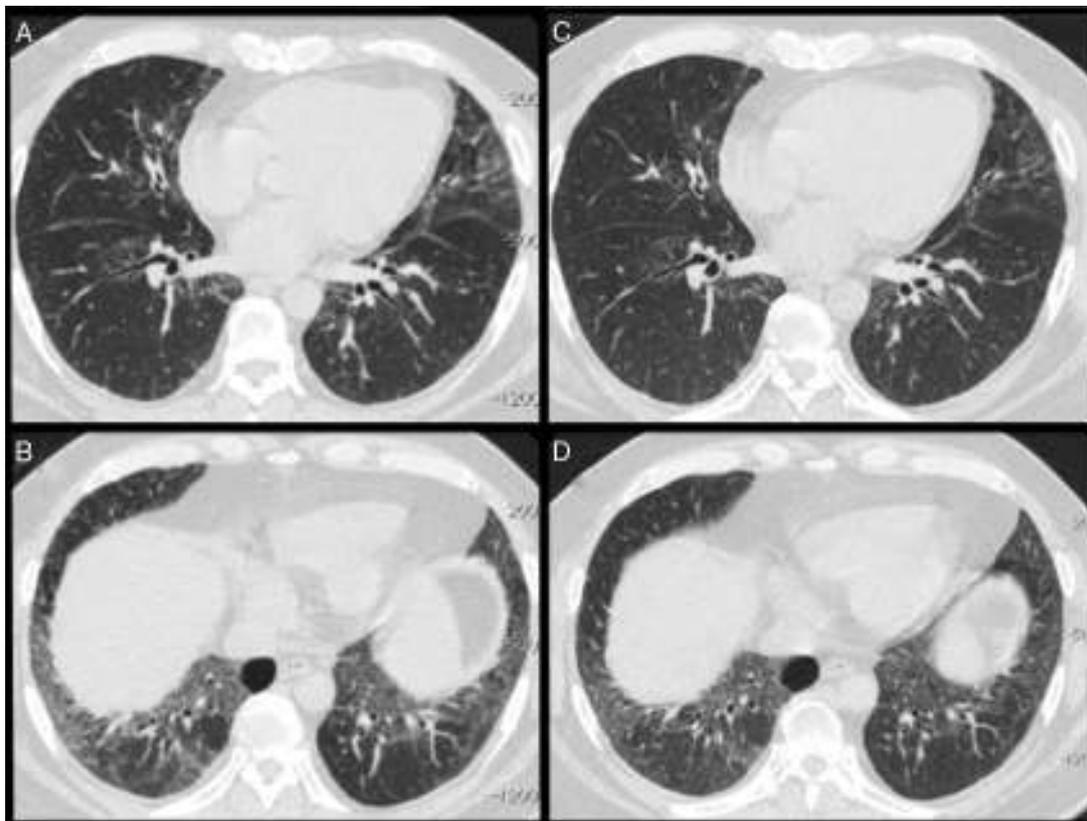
(A and B) High-resolution computed tomography showing raised diaphragm, ground glass opacities, interlobular thickening, and traction bronchiectasis predominantly in the lower lobes, a pattern compatible with non-specific interstitial pneumonia. (C and D) CT scans after rituximab treatment showing improvement in ground glass opacities.
